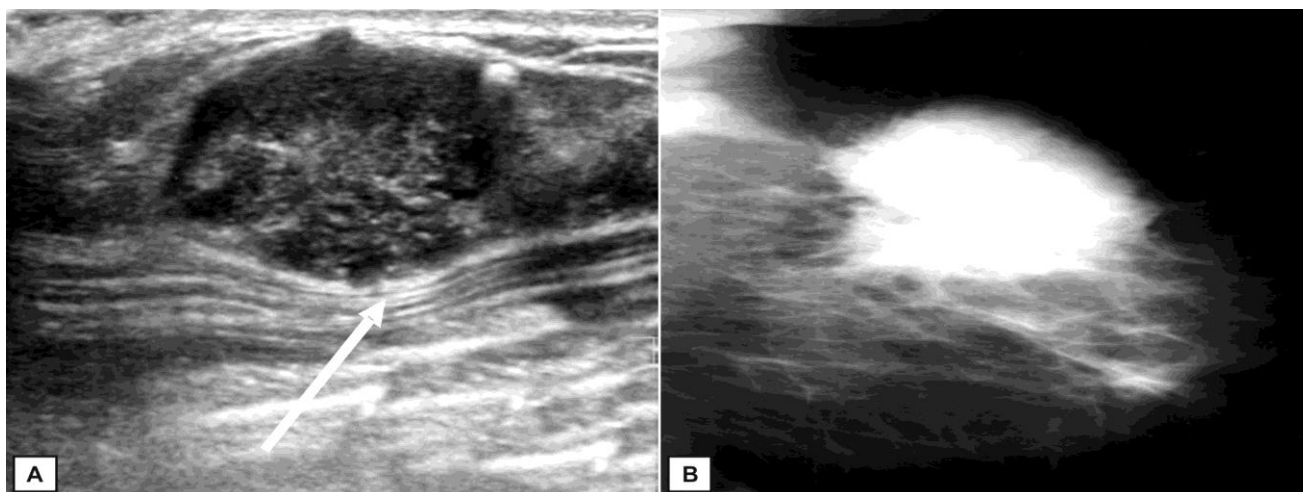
Radiographic image indicating ultrasonograph (A) and mammographic picture (B) of patients showing irregular breast lump.
